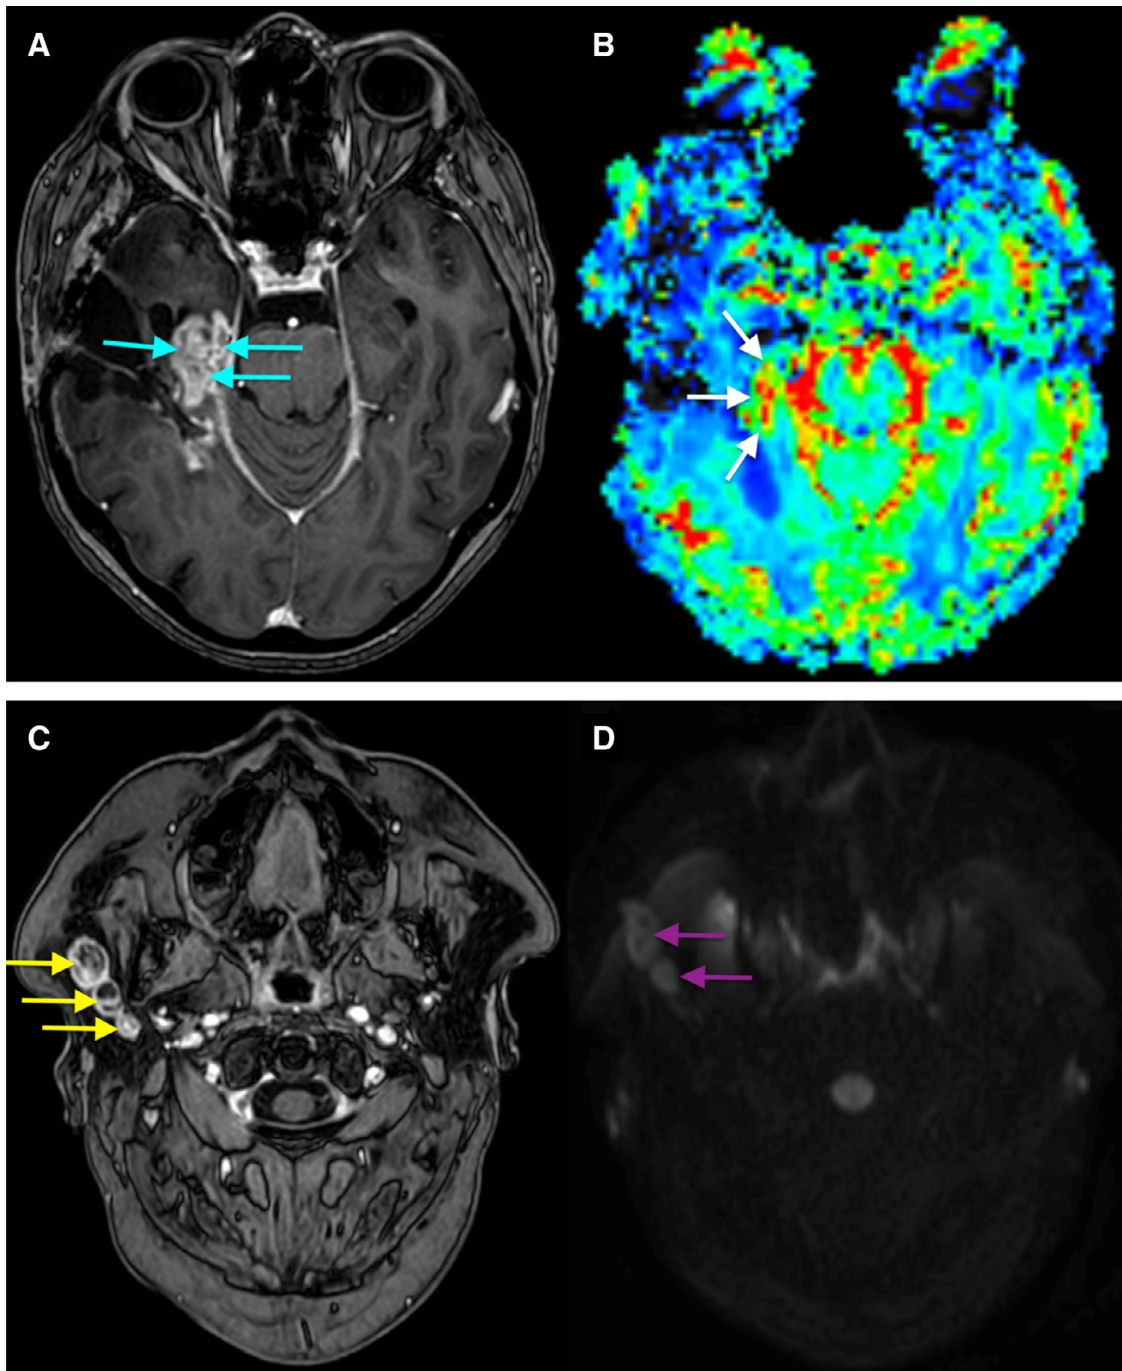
MRI of the brain 5.5 months after presentation. (A) Gadolinium-enhanced T1-weighted image showing a volume increase of local recurrence. (B) Perfusion-weighted imaging demonstrating an increased relative cerebral blood flow (rCBF) in the area of recurrence. (C) Gadolinium-enhanced T1-weighted image showing a moderate volume increase of the parotid nodules. (D) On B1000 imaging, the parotid nodules had also grown in volume. On this examination, the parotid nodules were detected.
